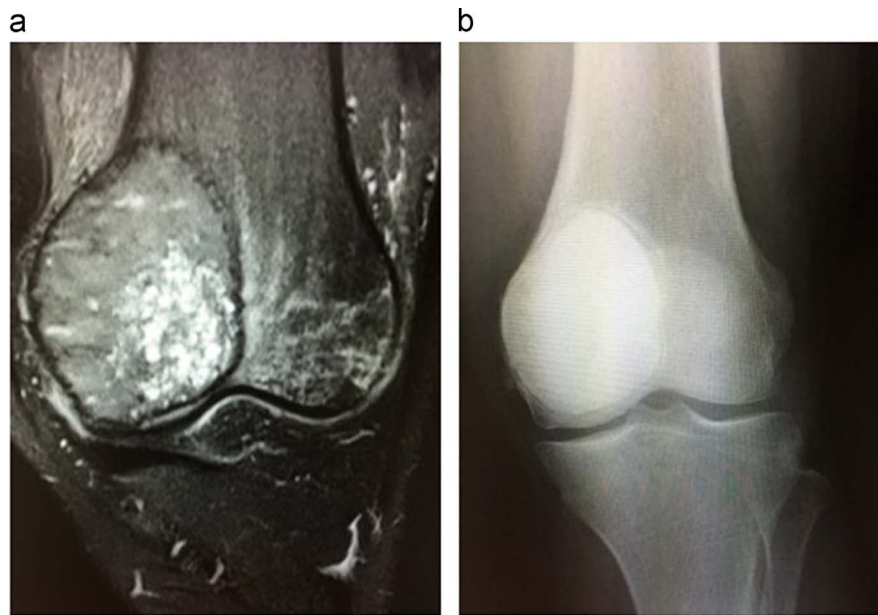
Giant cell tumor of the distal femur seen on MRI characterized by a heterogeneous, epiphyseal metaphyseal mass expanding the medial femoral metaphysis; Plain x-ray reveals cementation after curettage and cryoablation using two freeze thaws. a) Initial evaluation; b) Post-operative outcome.
